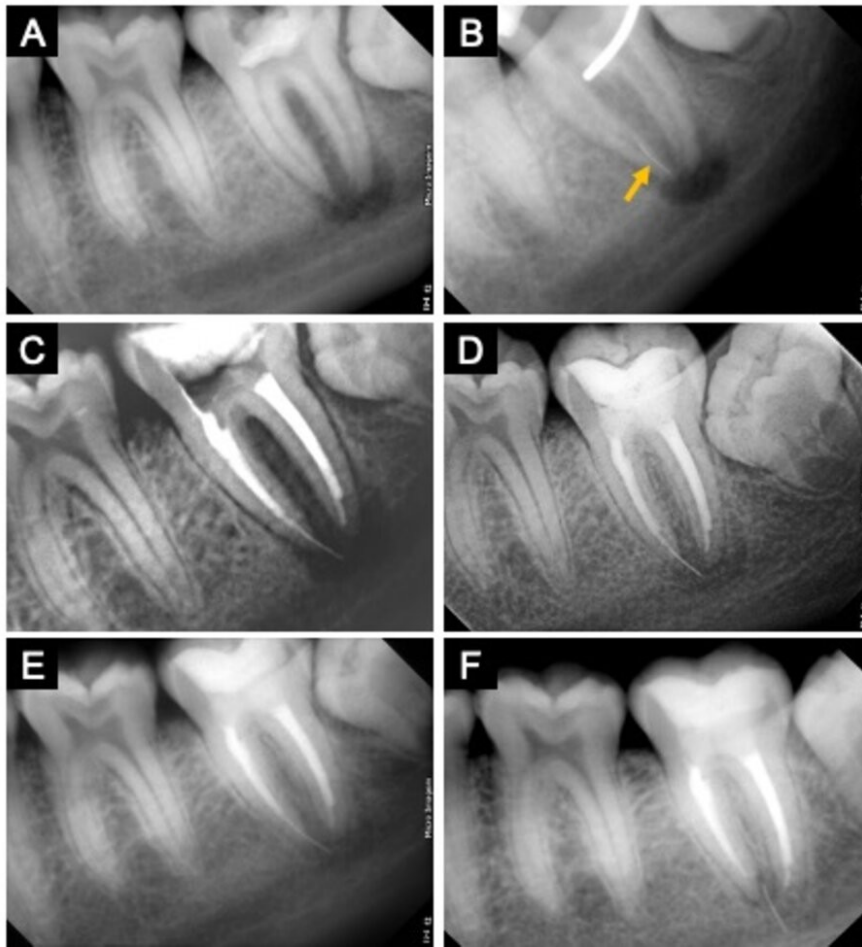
Radiographic images of case 1: A) Preoperative radiograph of the left mandibular second molar (tooth 37) showing periapical radiolucent lesion; B) Radiograph after biomechanical instrumentation showing a fragment of the XP-Clean instrument (yellow arrow) within the mesiobuccal canal; C) Radiograph after endodontic root canal filling; D) 6-month follow-up; E) 12-month follow-up; F) 18-month follow-up showing bone neoformation in the periradicular area.
